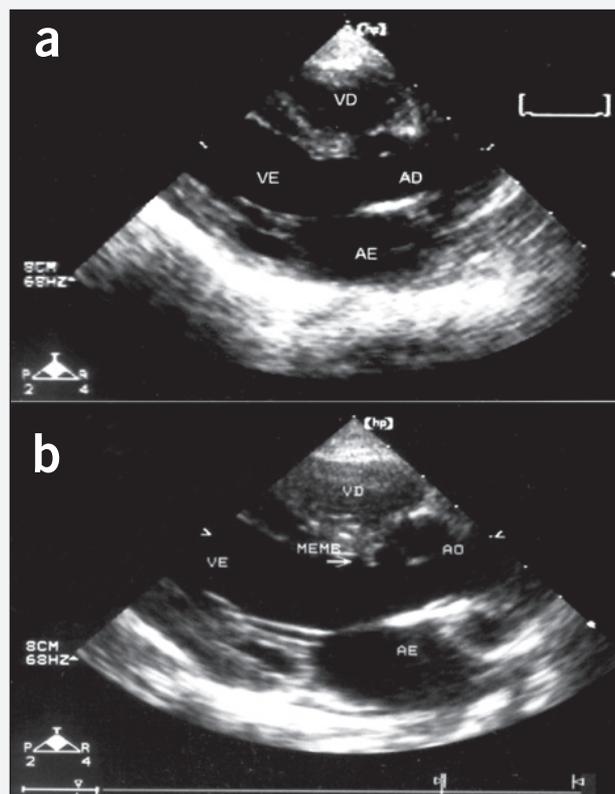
Echocardiographic images of left ventricular outflow tract of a child with a perimembranous septal defect, before (a) and after (b) the diagnosis of fixed subaortic stenosis. Difference in age of the child between the 1st and 2nd echocardiogram was 6 months (b).
